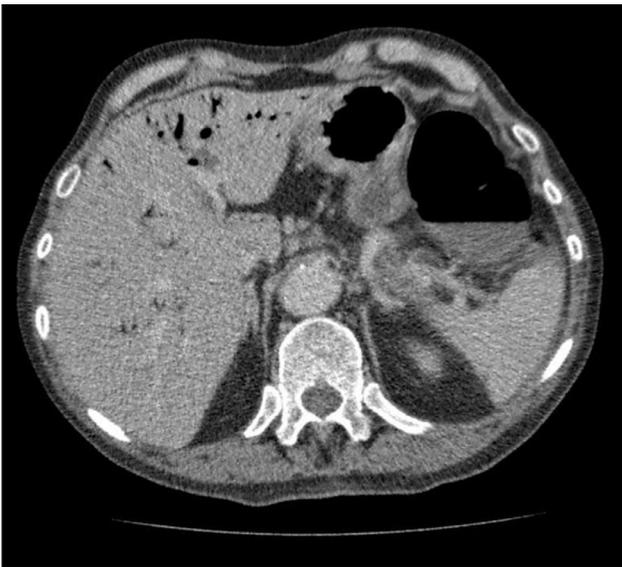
Axial computed tomography screenshot with pneumatosis seen in the periphery of the left lobe of the liver.
